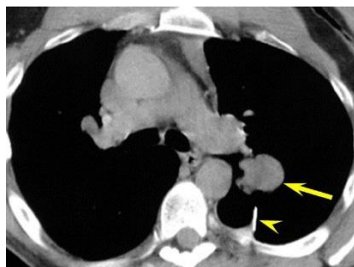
Axial unenhanced prone thoracic CT (image rotated to resemble the typical display of axial CT images) shows the fine needle aspiration biopsy needle (arrowhead) approaching the larger, more caudally located, pulmonary nodule (arrow).
